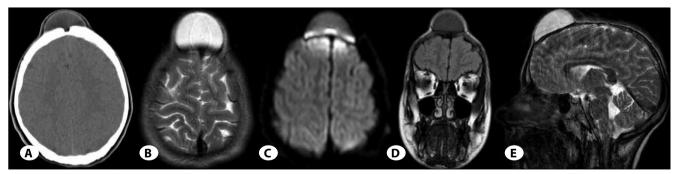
The BDC is isodense with the cerebrum on CT (A). It is hyperintense on T2W and FLAIRW MRI (B, E, D). On diffusion weighted-scan, the BDC has an isointense appearance (C). A) Axial CT image on cerebrum density, B) Axial T2W MRI, C) Diffusion-weighted axial MRI, D) Coronal FLAIRW MRI, E) Sagittal T2W MRI.
